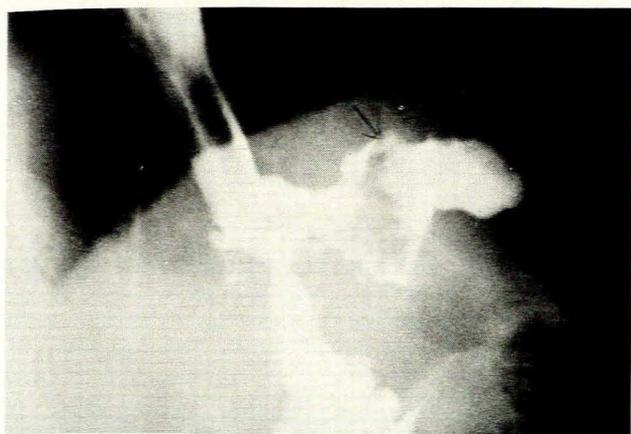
A large leak demonstrated on a radiograph 10 days after a total gastrectomy with a Roux-en-Y anastomosis.
